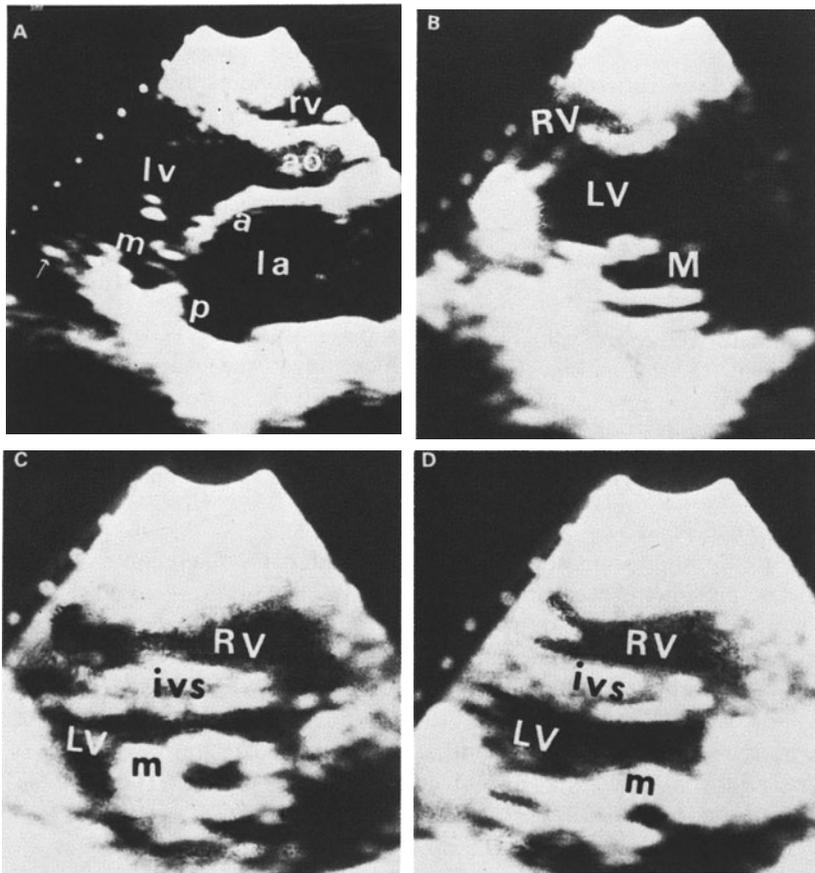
(A) Cross-sectional long-axis echocardiogram of a patient with rheumatic mitral stenosis. The anterior (*a*) and posterior (*p*) mitral leaflets are both thickened and the anterior leaflet shows systolic angulation. The arrow points to the subvalvular apparatus, with thickening and fusion of chordae tendineae (*m*, mitral valve; *la*, left atrium; *ao*, aorta. Other abbreviations are as in Figure, 1B, 1C, and 1D. (B, C, and D) Cross-sectional short-axis echocardiogram in patients with moderate (B), severe (C), and very severe (D) rheumatic mitral stenosis. The degree of fusion of the posteromedial and the anterolateral commissures is well shown in each case (*RV*, right ventricle; *LV*, left ventricle; *m*, mitral valve; *ivs*, interventricular septum).
